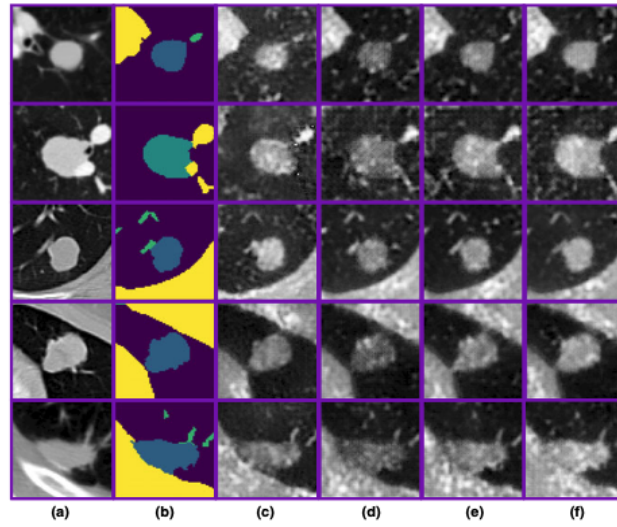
Semantic generation: (a) Real CT; (b) Semantic labels; (c) Images without nine attributes. (d), (e), and (f) images with nine attributes and texture scores are 1, 3, and 5, respectively. From [68].
